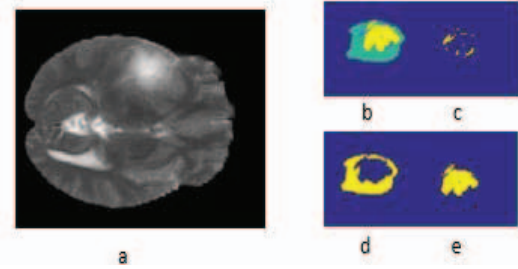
Sample of an MRI image from the BraTS dataset: a) slice of T1-enhanced MRI, b) the three tumor labels, c) NCR/NET region, d) edema region, and e) enhanced tumor.
